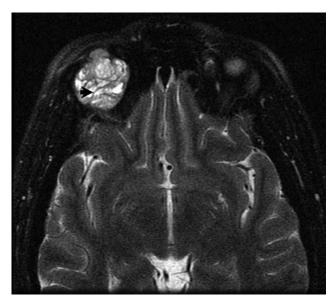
T2-weighted fat-suppressed MRI showing a hyperintense, irregular mass with linear septations (arrowhead).
